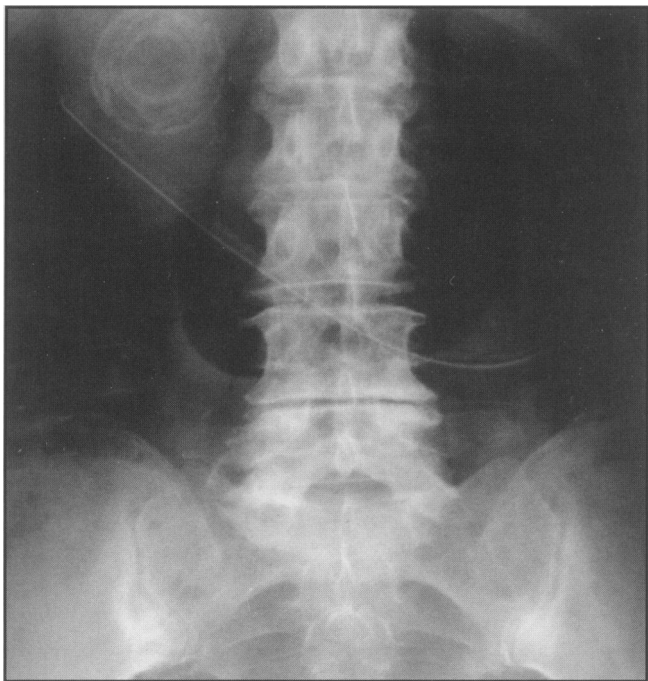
Plain abdominal X-ray demonstrating nasogastric tube and a large "doughnut" shaped calcified opacity on the right side of the first lumbar vertebra.
